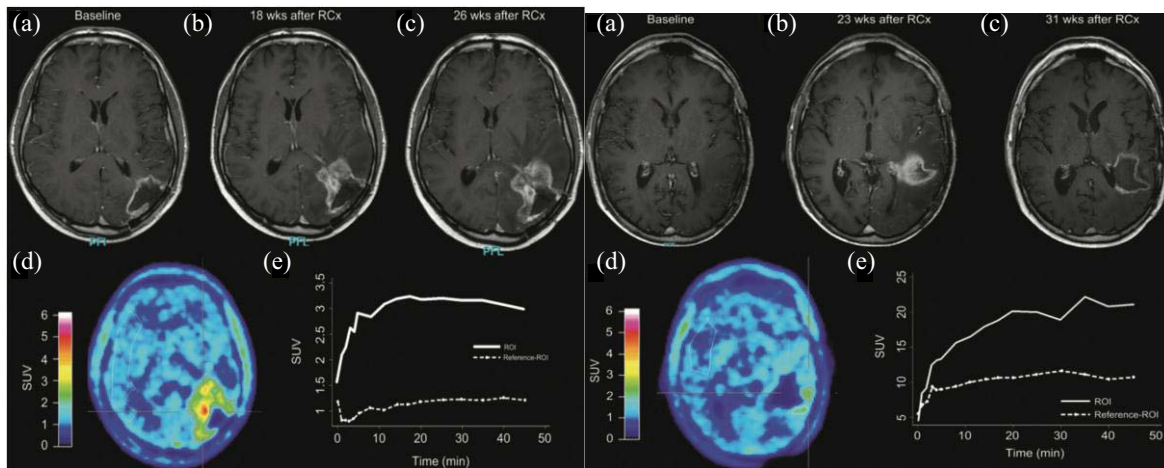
O-(2-[18F]fluoroethyl)-L-tyrosine PET imaging has the potential to improve the differentiation of pseudo-progression from true progression of brain tumors. The panel on the left displays an area of increased enhancement on MRI (top row) that also shows increased uptake of radiotracer on PET (bottom row) consistent with true progression. The panel on the right displays an area of increased enhancement on MRI (top row) that shows uptake of radiotracer on PET similar to background (bottom row) consistent with pseudo-progression.
